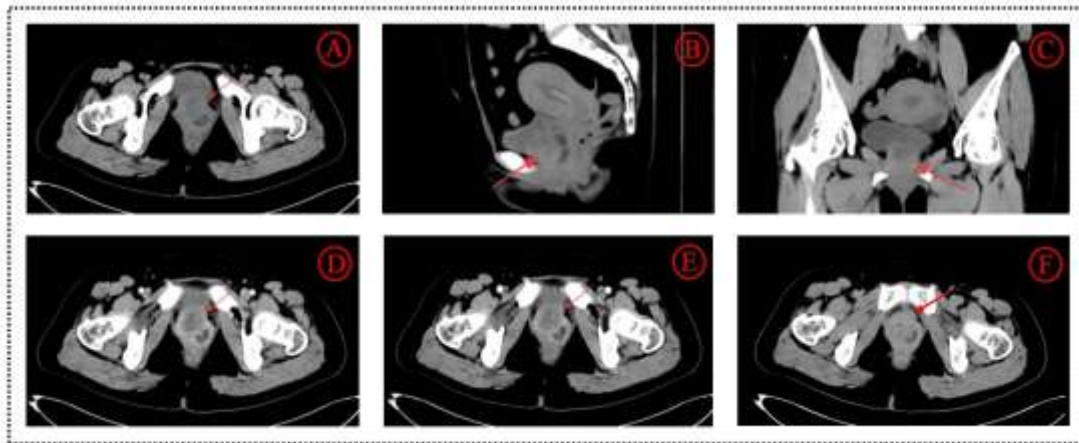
CT Images of NEC. On non-contrast CT scans, a soft tissue mass is observed along the course of the urethra (Figures A-C); on contrast-enhanced CT scans, the lesion exhibits heterogeneous annular enhancement (Figures D-E).
